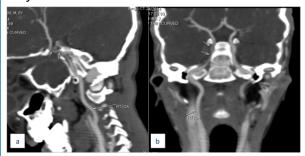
Reformatted sagittal (a) and coronal (b) CT angiography images showing mild focal narrowing of the cavernous segment of right ICA (arrows).
